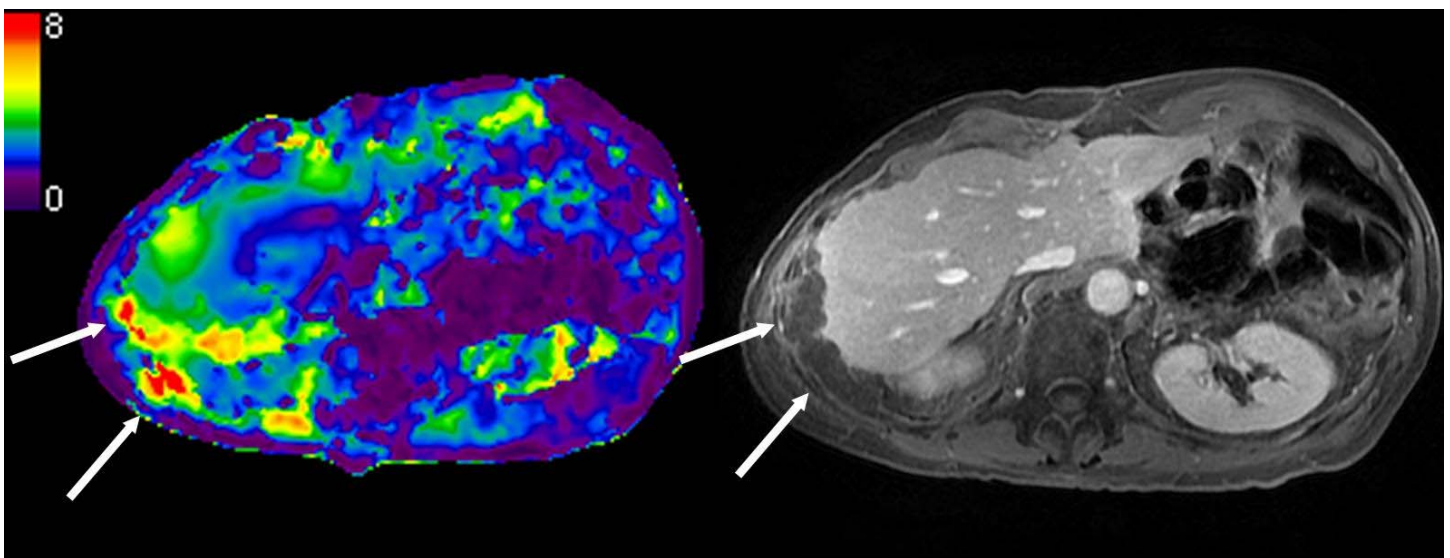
62 year old male with appendiceal cancer and pseudomyxoma peritonei. MR Elastogram (left) shows perihepatic tumor (arrows) with increased shear stiffness (6.2 kPa) compared to the mean liver 1.8 kPa. Delayed gadolinium-enhanced MRI right confirms the moderately bulky right subphrenic mucinous tumor (arrows).
